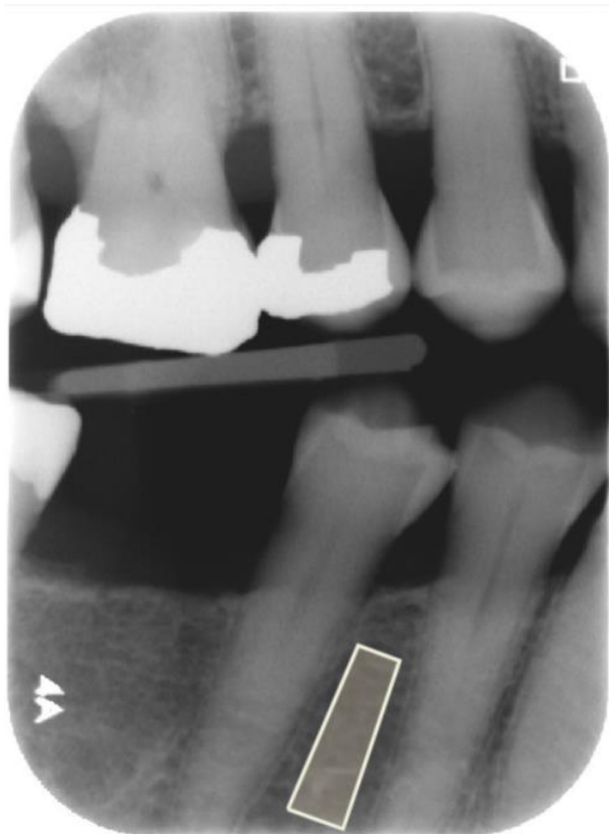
An example of a dental radiograph uploaded to the software with the trapezoid marker symbolising ROI manually placed between the roots/apices of premolar area in the lower jaw. ROI, region of interest.
